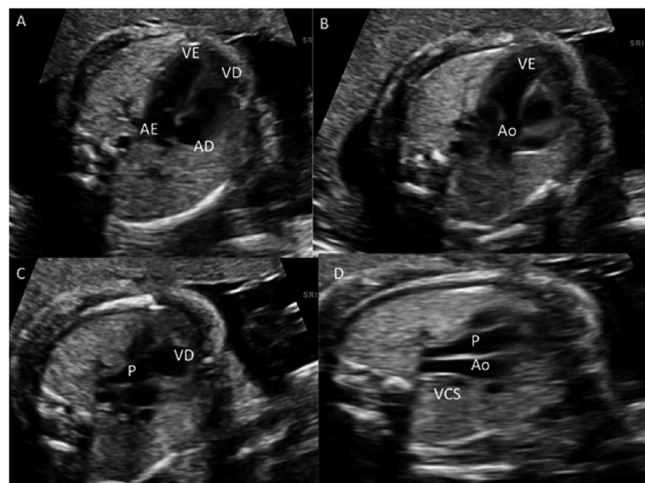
Images for evaluating the fetal cardiac screening by two-dimensional ultrasound. A: four-chamber view of the fetal heart. B: left ventricular outflow tract (LVOT). C: right ventricular outflow tract (RVOT). D: three-vessel view of the fetal heart. LV: left ventricle. RV: right ventricle. LA: left atrium. RA: right atrium. P: pulmonary artery. Ao: aorta. SVC: superior vena cava
